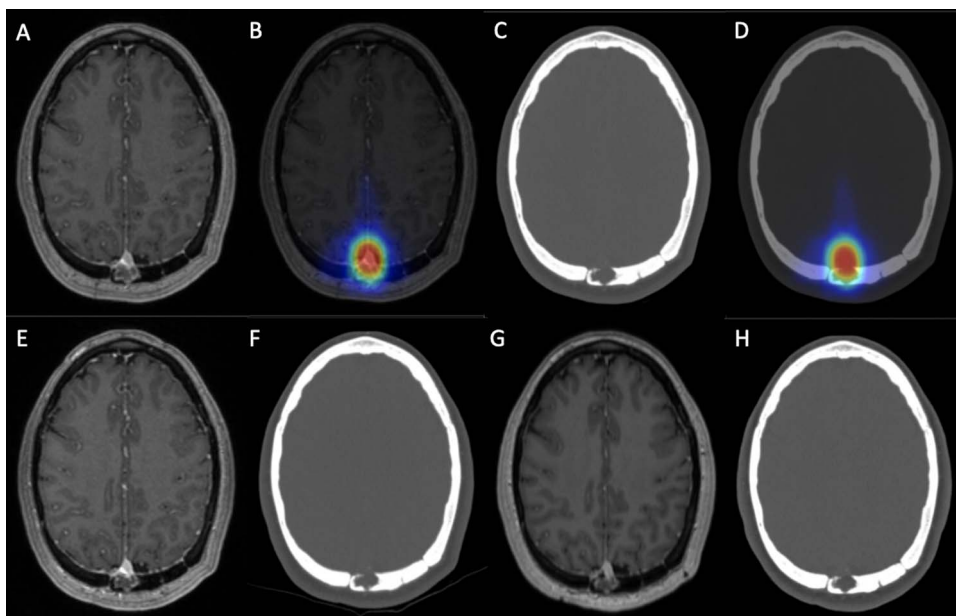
Case 1 at initial presentation and subsequent follow-up of osteolytic lesion. Identical serial T1 post-contrast MRI axial slices obtained (A, B) at the time of the development of the lytic bone lesion 5 years post-SRS, with (B) showing the radiation isodose overlay (red corresponds to higher dose, blue to lower dose); identical CT head axial slices (C, D) at the time of the development of the lytic bone lesion 5 years post-SRS, with (D) showing the radiation isodose overlay revealing that the lesion is in the high-dose region; (E) T1 post-contrast MRI 6 months after the development of the lytic bone lesion and (F) comparable CT at the same timepoint; (G) T1 post-contrast MRI 1.5 years after the development of the lytic bone lesion and (H) comparable CT slice at the same timepoint.
